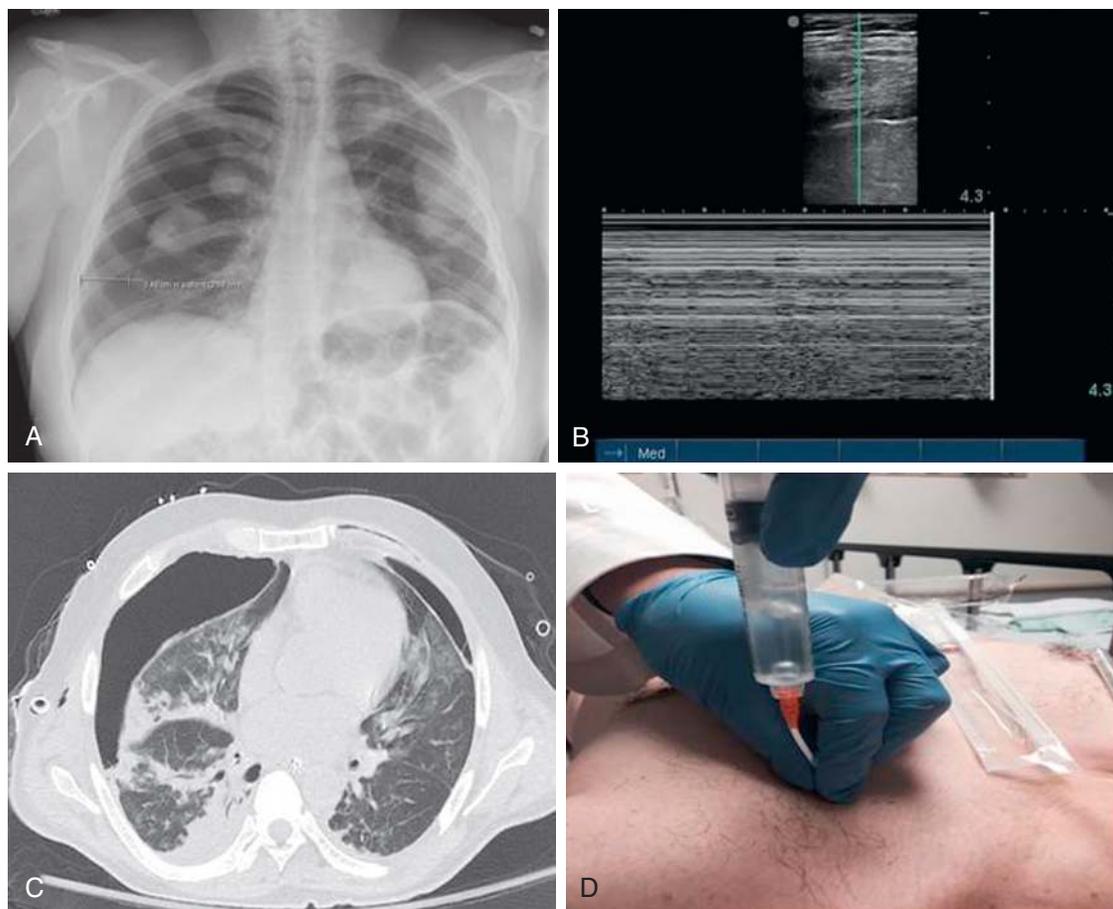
Different Modalities for Diagnosing Pneumothorax. A, Chest x-ray. B, US M-mode. C, CT scan. D, Needle aspiration. *CT*, Computed tomography; *US*, ultrasound.
